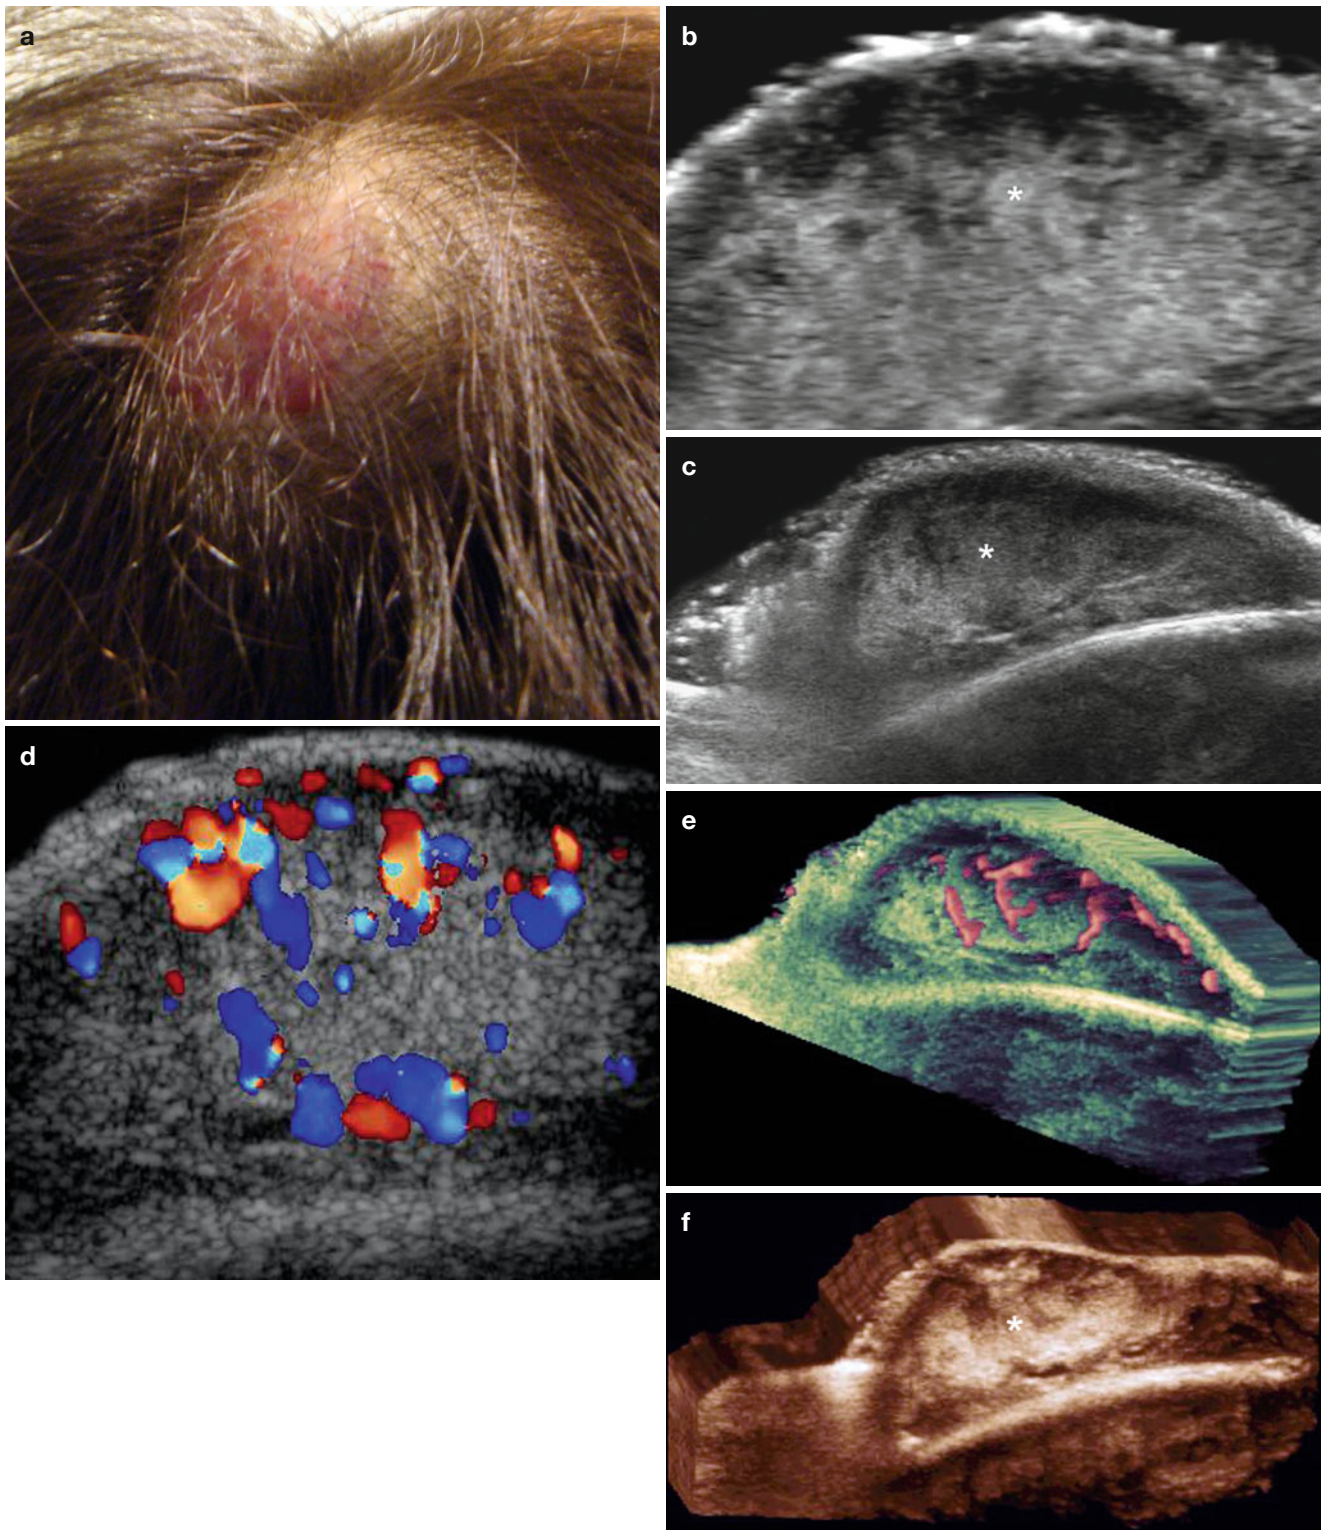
(a–f) Hemangioma (partial regression phase). (a) Clinical erythematous lesion in the scalp. (b) Grey scale ultrasound image (transverse view) and (c) Grey scale ultrasound image (extended transverse view) shows a mixed echogenicity ill-defined mass (*) that involve dermis and subcutaneous tissue (*). (d) Color Doppler ultrasound
